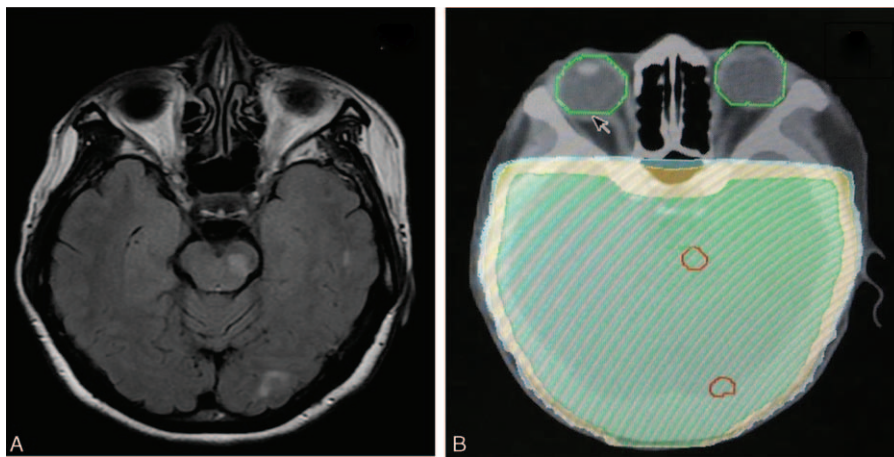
(A) One of T1-weighted images brain magnetic resonance imaging (MRI) showed multiple brain metastases. (B) Brain computed tomography showed the target area (the green-filled area) of whole-brain radiotherapy region.
